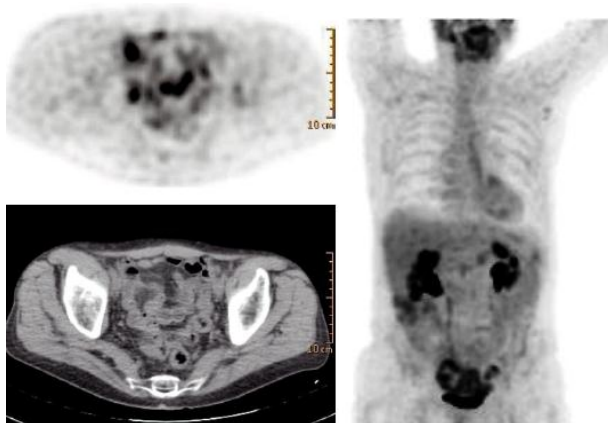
shows Aspecific bowel FDG uptake one of the causes of false positive results ⁽³⁾.
